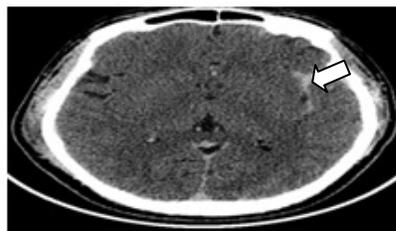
Axial plain CT shows grade 1 SAH in left sylvian fissure
